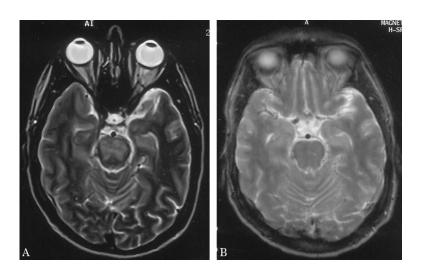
(A) T2-weighted image (repetition time 4000, echo time 95) shows pontine edema. (B) T2-weighted image 2 weeks later (repetition time 3657, echo time 96) shows almost complete resolution of the abnormal findings.
